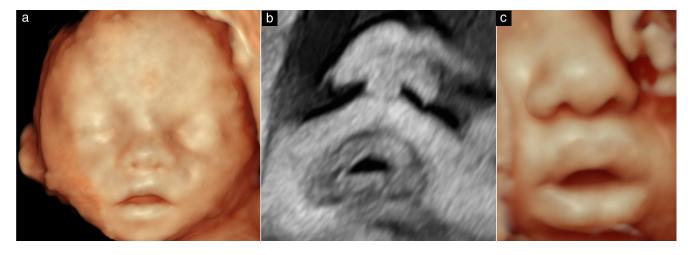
Subtle signs of congenital hypotonia on ultrasound imaging: open/tent-shaped mouth in cases of: (a) presumed hypotonia and (b,c) spinal muscular atrophy, subtype 'lower-extremity predominant', on two-dimensional (b) and three-dimensional (a,c) imaging (see also Videoclip S1).
